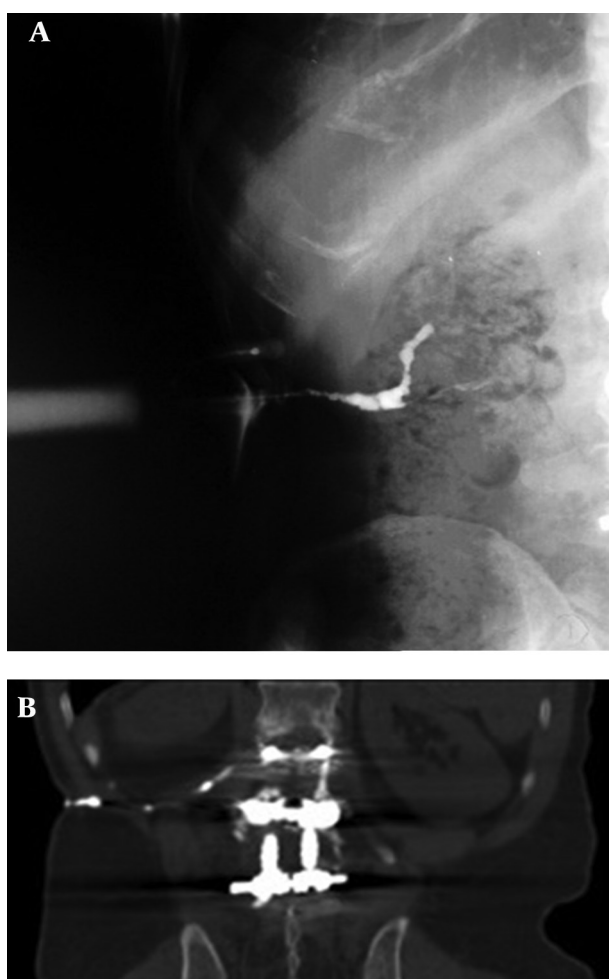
Fistulography; A, CT Fistulography; B, Coronal view.
